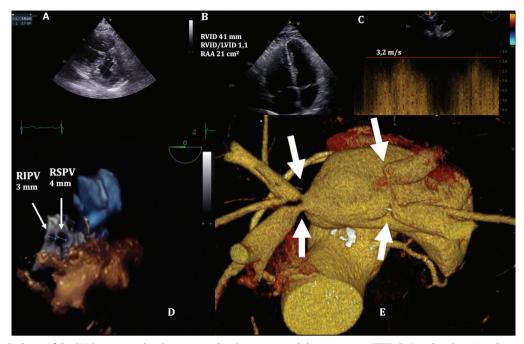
A. D-shape of the RV during systole when assessed in the parasternal short-axis view (TTE); B. A 4-chamber view showing dilated right heart cavities (TTE); C. Significantly increased flow velocity in CW in the PV (up to 3.2 m/s, pressure gradient 41 mm Hg) (TEE); D. The significantly narrowed PV ostium (3-dimensional TEE reconstruction); E. Confirmation of the diagnosis of PVS — sites of narrowing marked with the white arrows (CT)
